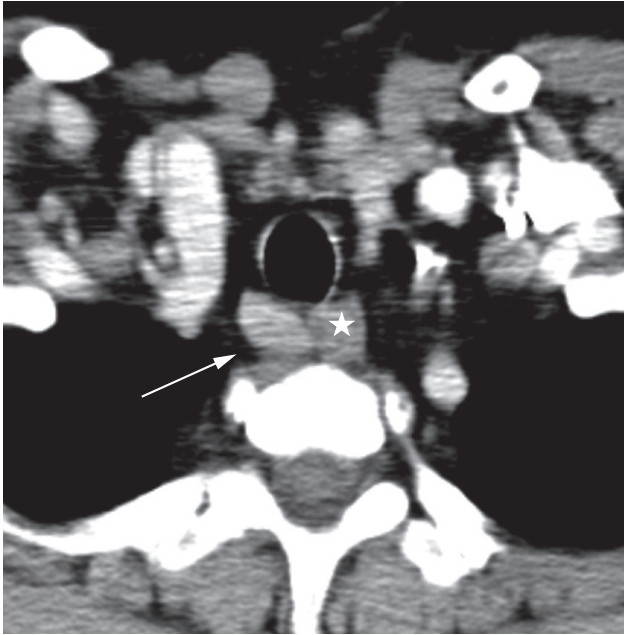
CT of the neck showing an ectopic right retrotracheal adenoma (arrow) lying next to the esophagus (*).
